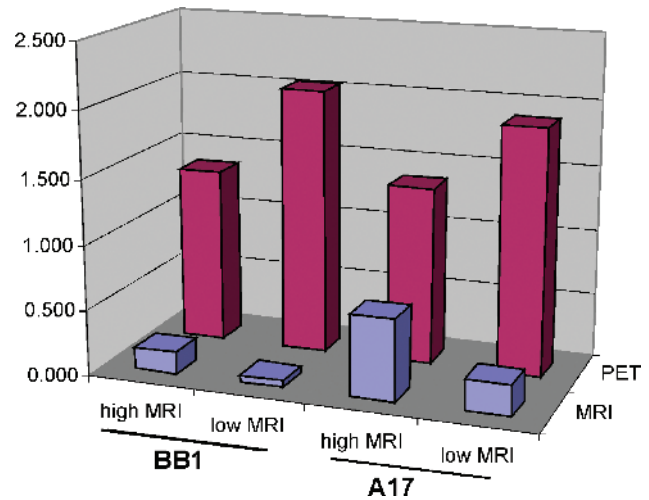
Comparative analysis of MRI enhancement in carcinomas (BB1) and mesenchymal tumors (A17). In both BB1 and A17 tumors, FDG uptake proved higher in high-MRI- than in low-MRI-enhanced regions.
